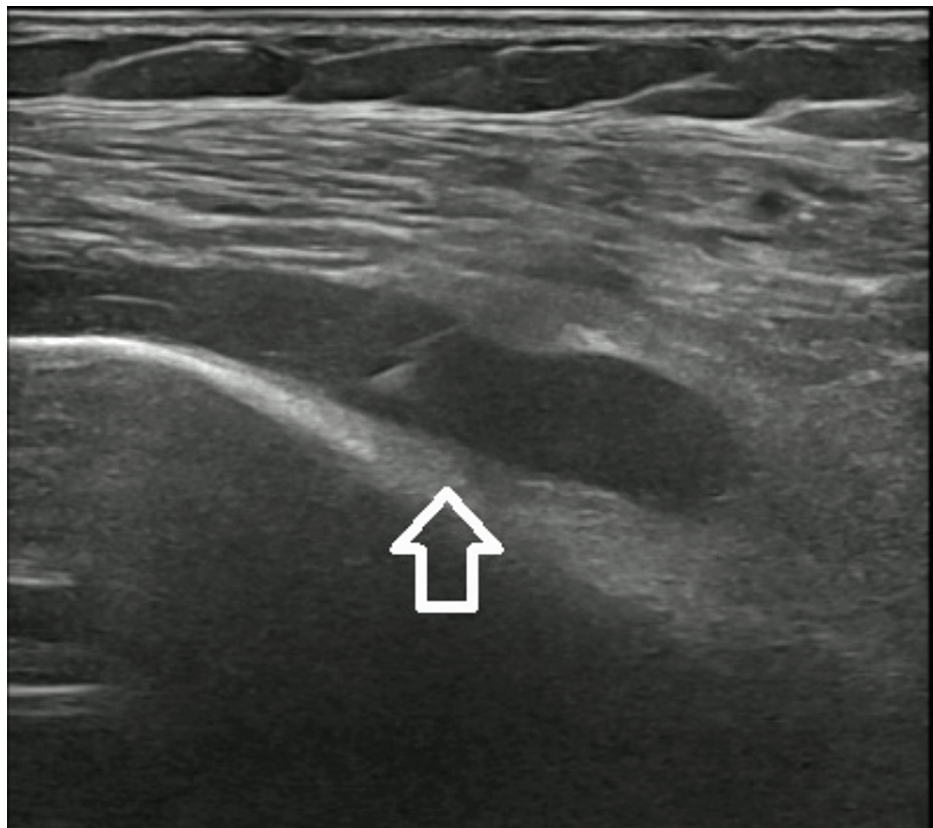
Left shoulder ultrasound revealing hypoechoogenic fluid collections.
